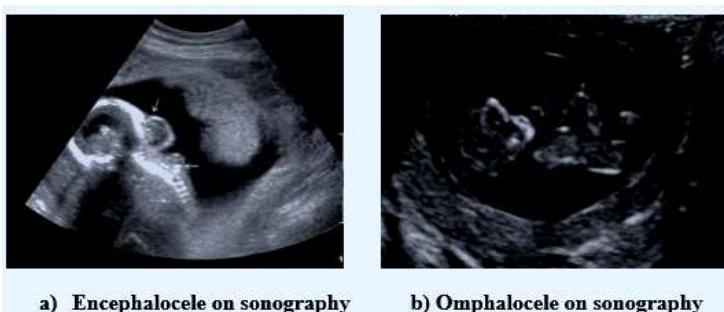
Fetal anomalies on ultrasonography
